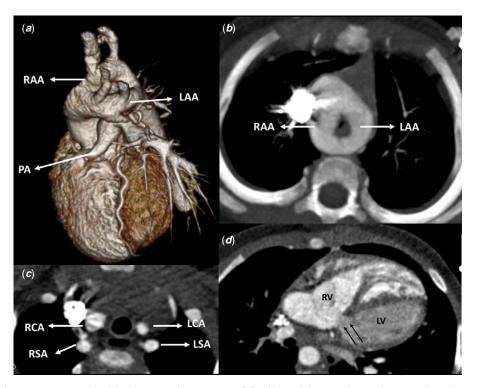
CT angiography. (a) Tridimensional reconstruction (left-sided view) depicting the vascular ring, with similar size right (RAA) and left-sided aortic arch (LAA), the pulmonary atresia (PA) and the origin of the neck vessels; (b) Axial plane, maximum intensity projection (MIP) image depicting the right and left aortic arches encircling the trachea; (c) Axial plane, depicting the origin of the neck vessels and their relation with the trachea – RCA, right carotid artery; RSA, right subclavian artery; LCA, left carotid artery; LSA, left subclavian artery; (d) Axial oblique reformation, showing a large ventricular septal defect (black arrows) – RV, right ventricle, LV, left ventricle.
